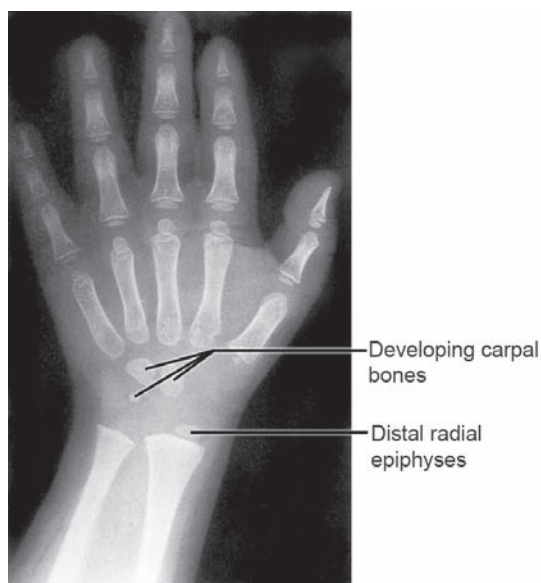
Bone age: X-ray of the left hand and wrist of a boy aged 4 years and 3 months. The bone age using the TW II 20-bone score (Tanner-Whitehouse) is 3.8 years which is just below the 50th percentile for his age
